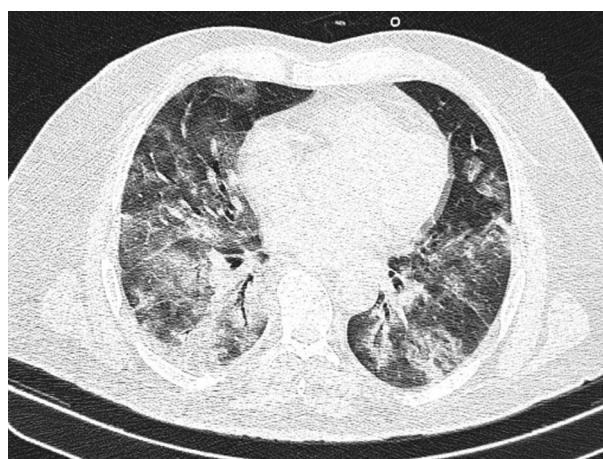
Figure/table-6: Axial HRCT chest image shows subpleural distribution of ground glass opacities.
